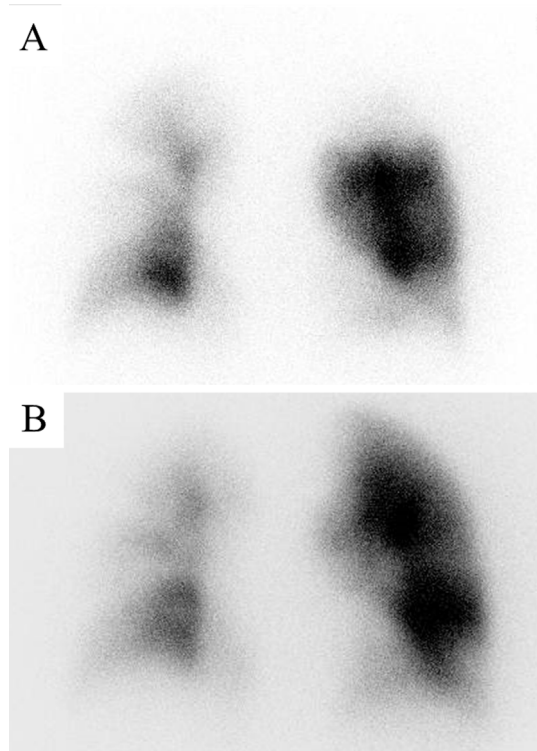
Lung perfusion scintigraphy conducted before anticoagulant therapy (A) and after 15 days of anticoagulant therapy (B). The left upper lung field improved, and the right lung tended to be slightly better overall.
